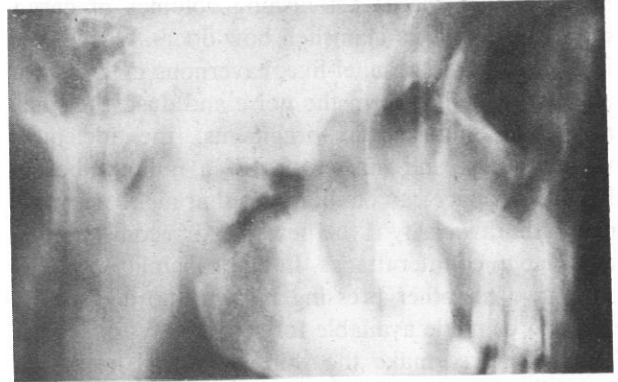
Postoperative roentgenogram showing site of osteotomy and coronoidotomy.
